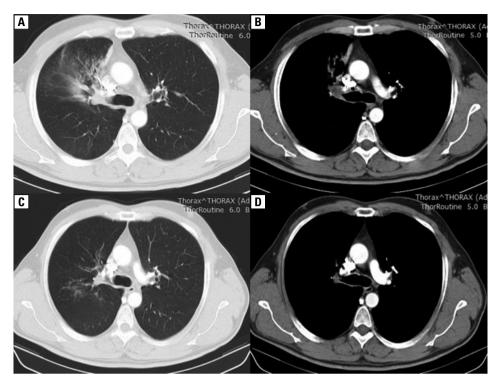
Chest Computed Tomography (CT) demonstrating infiltration in the right upper lobe (A, B). A second chest CT was performed two months later showing improvement of infiltrations; yet, a suspicious area of pathologic tissue in the right upper bronchus (C, D)
